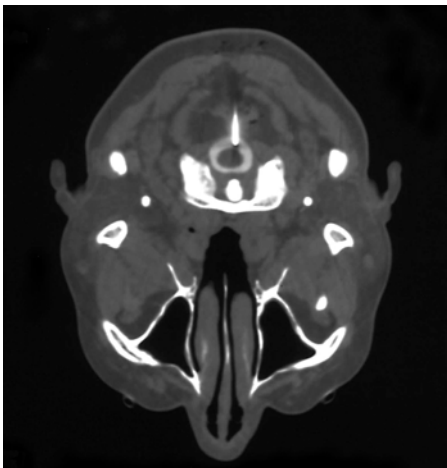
Final position of the cannula on axial CT scan at occiput-C1 level in TR-NC
